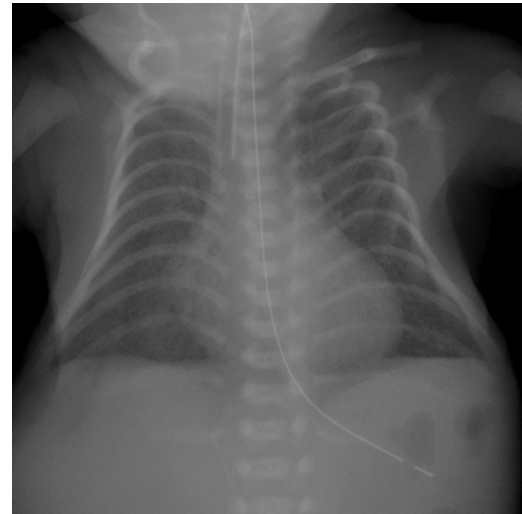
Coat-hanger ribs in a neonate with paternal uniparental disomy 14. Frontal chest radiograph shows a bell-shaped thorax with cranially directed posterior ribs and caudally directed anterior ribs, resulting in a coat-hanger appearance.
